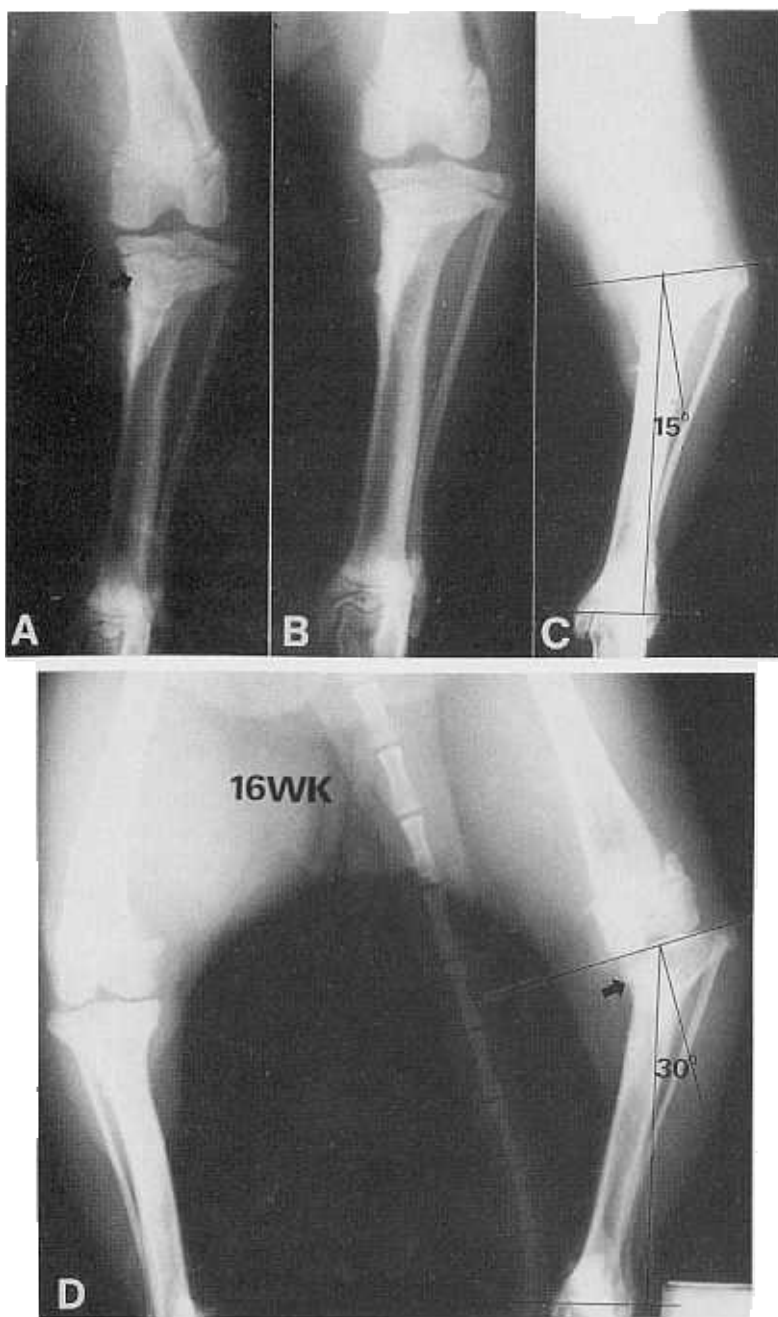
Serial radiographic changes after epiphyseal defect formation on the medial aspect of left proximal tibia.
